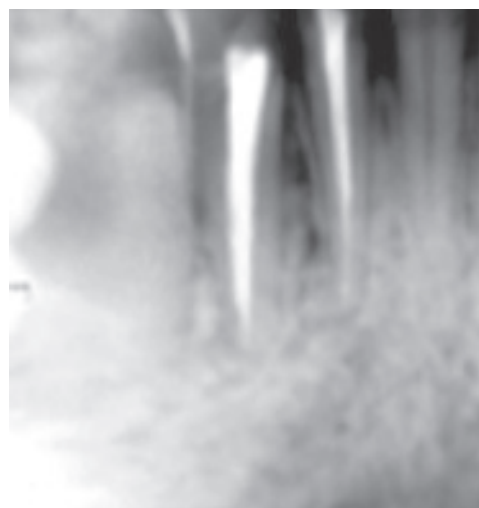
Radiograph after 12 months, revealing complete repair*
